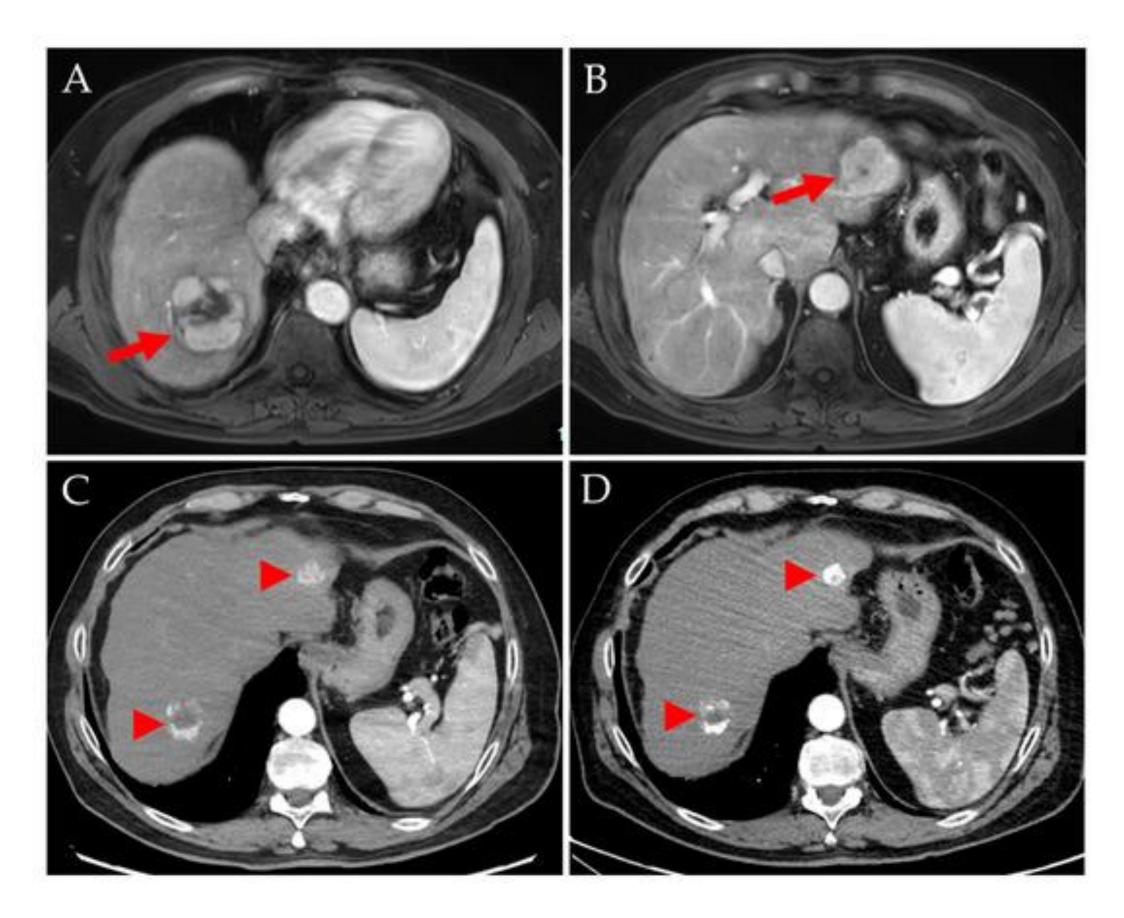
Complete remission after bilobar sequential TARE treatment of a 68-year-old man with HCC stage IIIA, MR imaging (A,B; T1-weighted fatsaturated sequence with contrast enhancement) shows multiple hypervascular lesions with a diameter of up to 5.3 cm (A, arrow). A follow-up CT scan 3 months after TARE revealed complete remission of all lesions according to the mRECIST criteria (C, arrowheads), the largest lesion measuring 2.8 cm. Further shrinkage was observed after another 4 months (D). The hyperdense areas in the regions of highest microsphere density are a typical finding after 166Ho-TARE.
